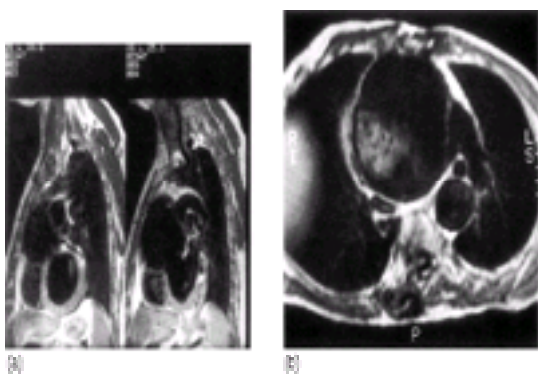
MRI scan showing a massive chronic ascending aortic aneurysm containing thrombus: (a) longitudinal section; (b) transverse section.
